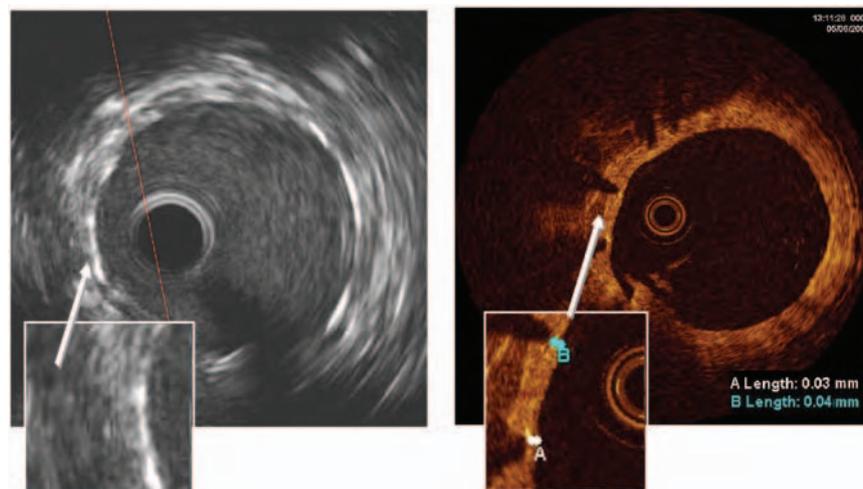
Corresponding images by intravascular ultrasound and optical coherence tomography 3 years after drug-eluting stent implantation
